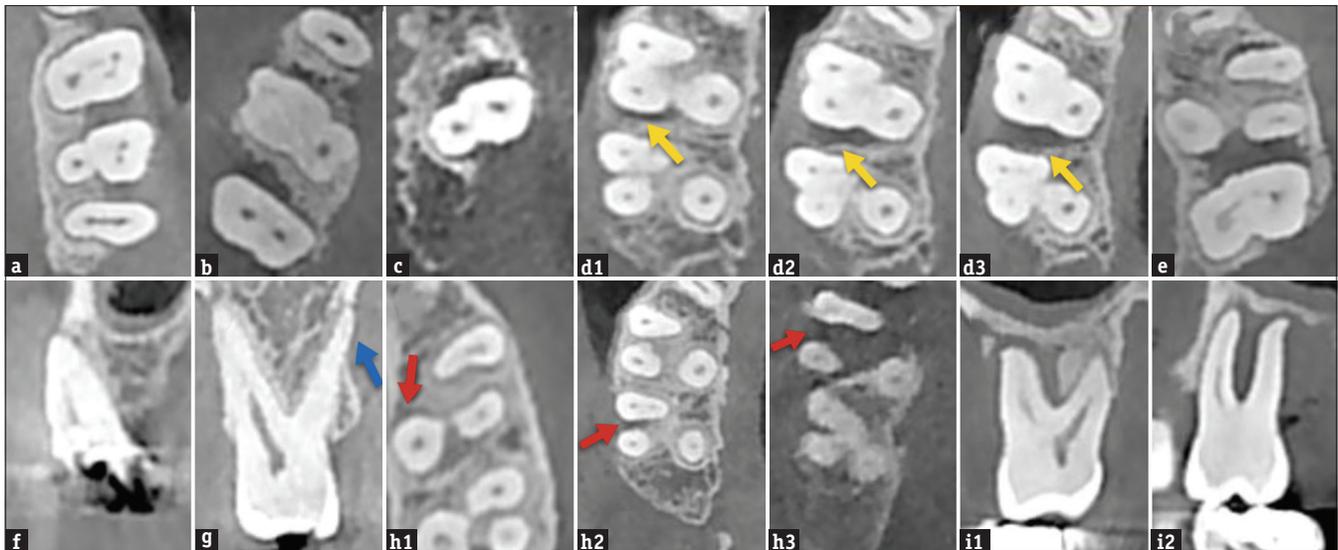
The cone-beam computed tomography images of various alveolar bone defects, furcation involvements and combined periodontal-endodontic lesion. One-walled vertical defects in interdental area of left maxillary molars (a). Two-walled vertical defect at mesial surface of second maxillary molar (b). Three-walled vertical defect on mesial surface of second maxillary molar (c). The number of walls in combined osseous defect on the distal surface of the first maxillary molar from apical to coronal sections (yellow arrows) (d1-d3). The crater at the interdental area of the maxillary molars (e). Dehiscence on the buccal surface of the maxillary molar (f). Fenestration on the palatinal surface of the maxillary molar (blue arrow) (g). Furcation involvements from Grade I–III (red allows) (h1-h3). Combine periodontal-endodontic lesion in coronal (i1) and sagittal (i2) sections
